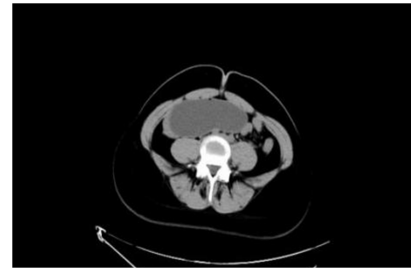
Pelvic CT coronal images.
